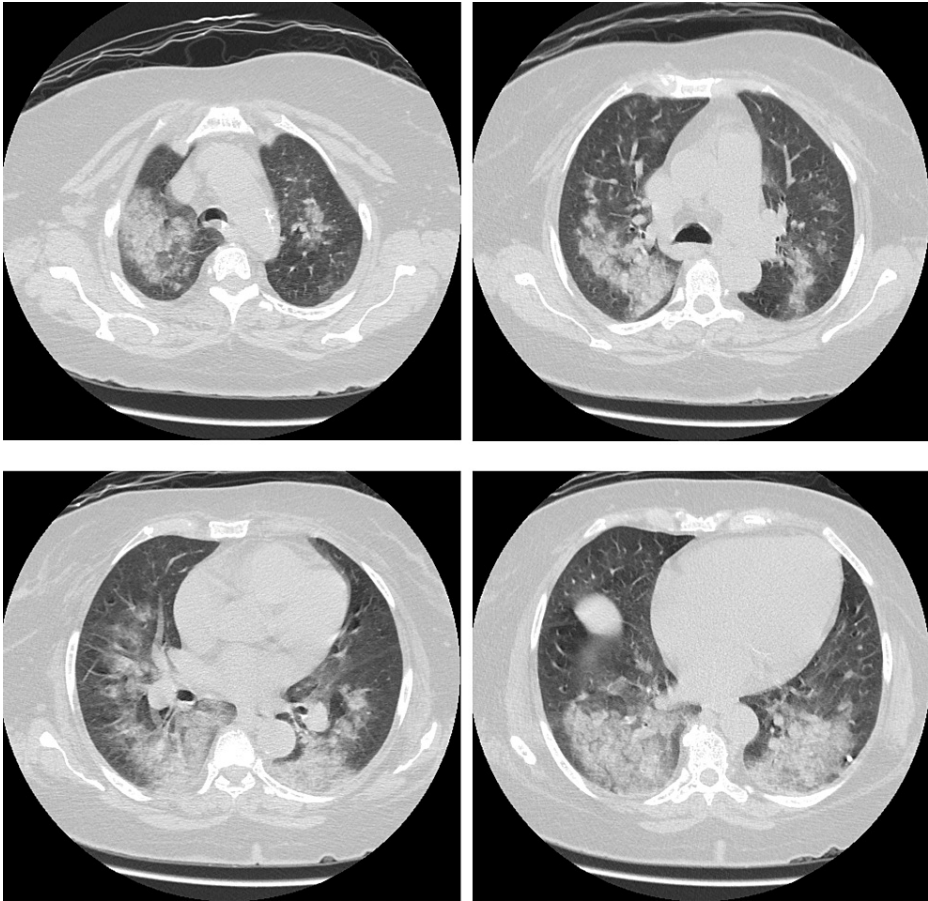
CT scan showing bilateral airspace opacity suggesting hemorrhage
